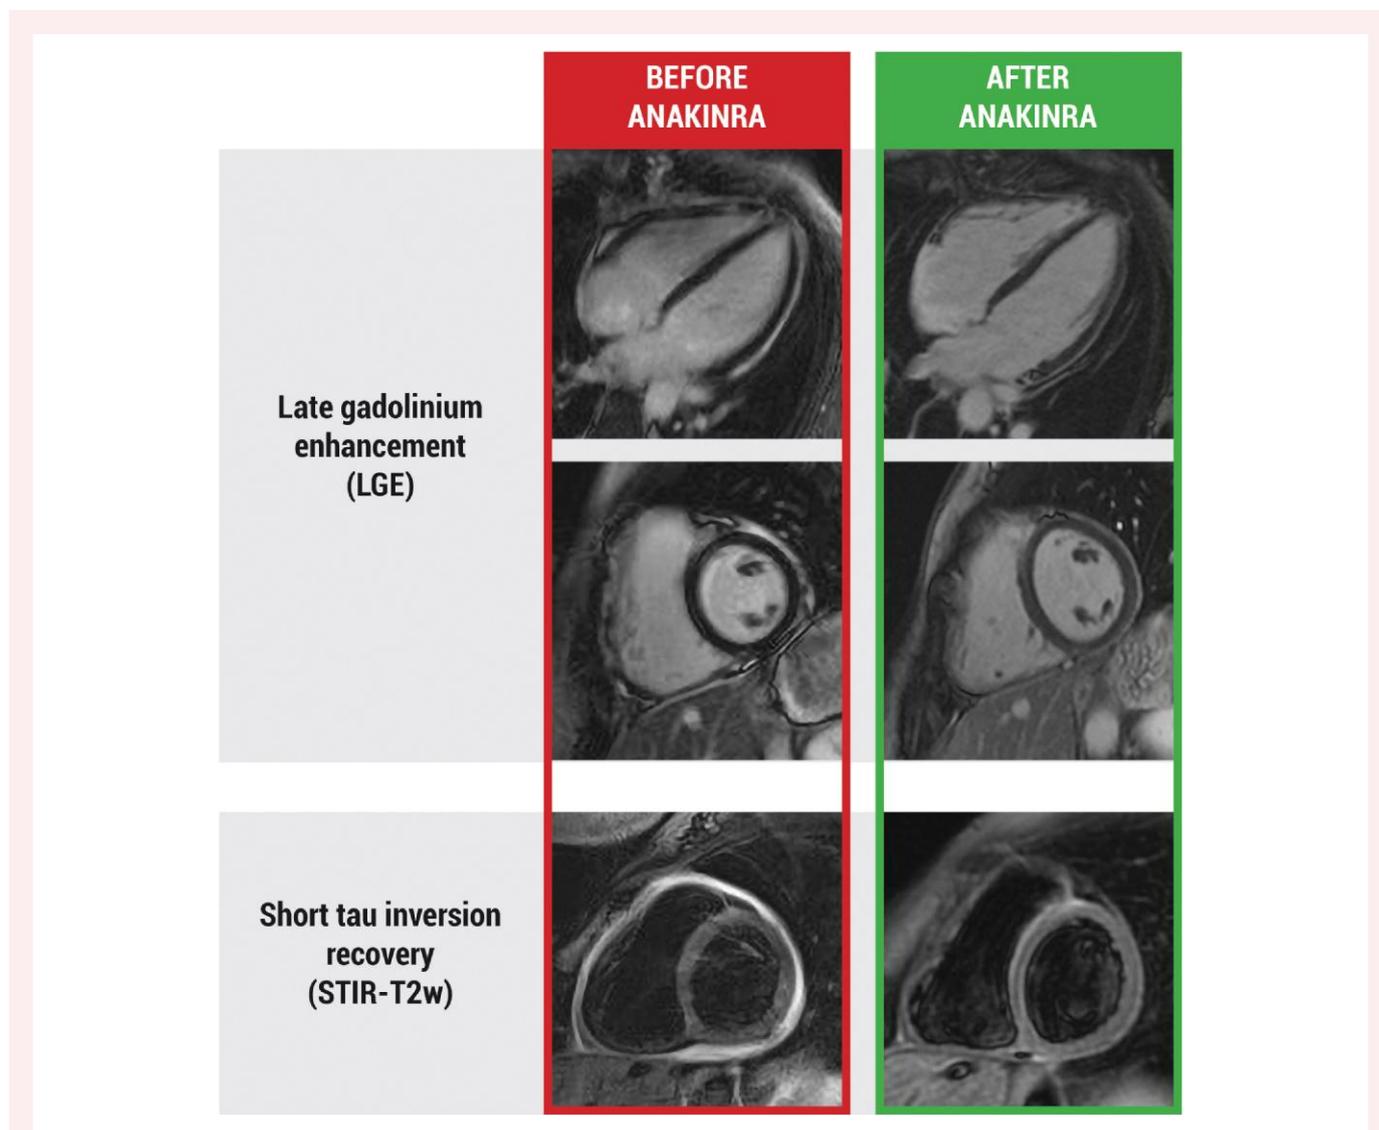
Cardiac magnetic resonance imaging showing significant regression of pericardial inflammation, with minimal residual pericardial late gadolinium enhancement (LGE) and no evidence of oedema on short tau inversion recovery (STIR-T2w) imaging after anakinra treatment.
